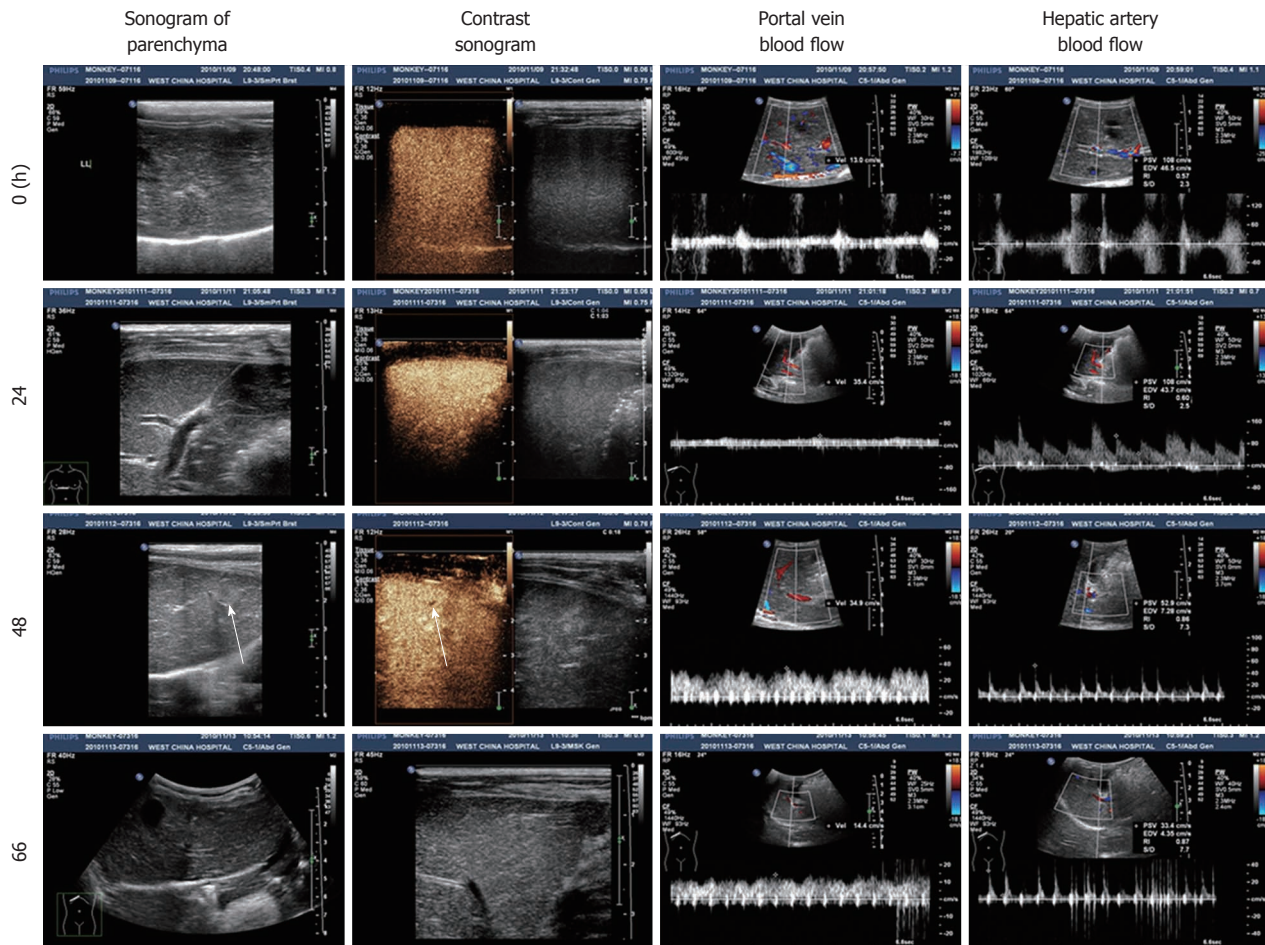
Liver sonogram of the *Macaca mulatta* model at different times. Arrows show a slightly enhanced echo and lower perfusion of SonoVue at 48 h.
